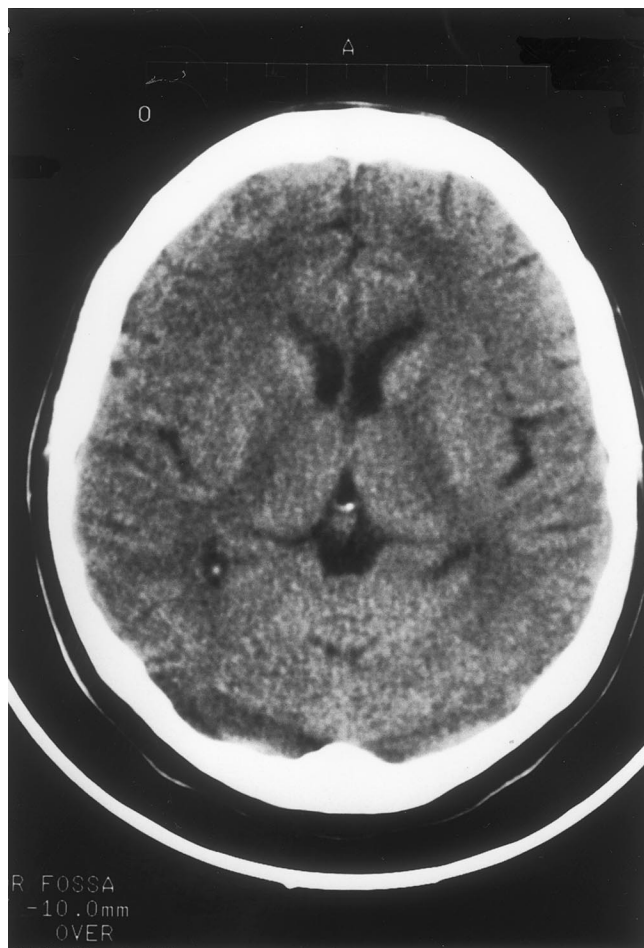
Cranial computed tomography showing complete resolution of subdural collections.
